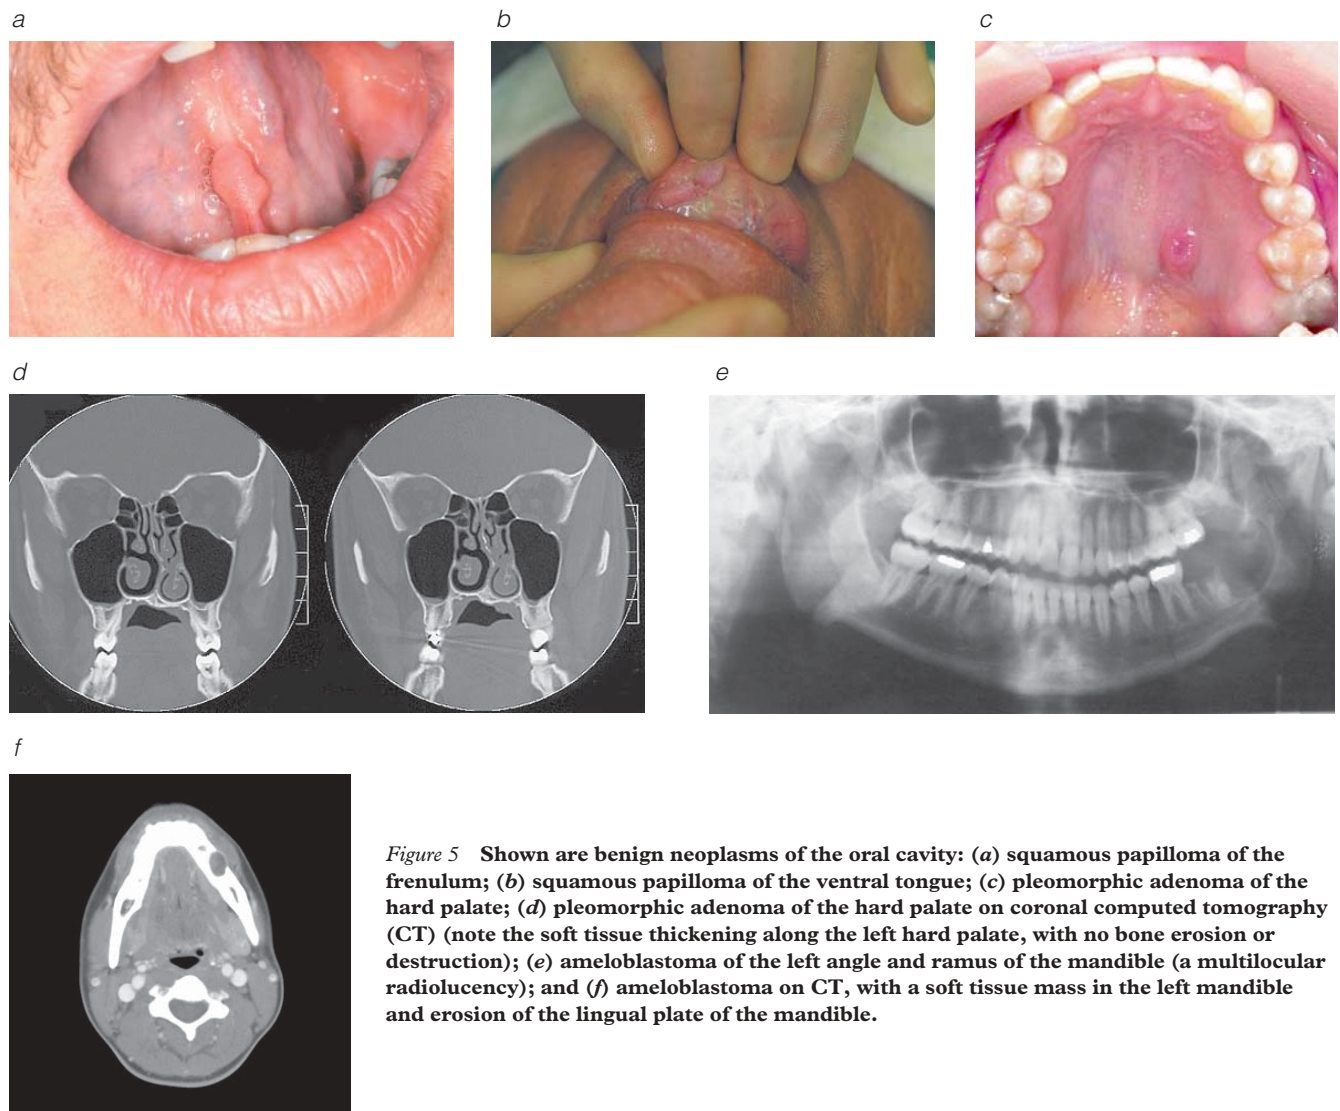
Shown are benign neoplasms of the oral cavity: (a) squamous papilloma of the frenulum; (b) squamous papilloma of the ventral tongue; (c) pleomorphic adenoma of the hard palate; (d) pleomorphic adenoma of the hard palate on coronal computed tomography (CT) (note the soft tissue thickening along the left hard palate, with no bone erosion or destruction); (e) ameloblastoma of the left angle and ramus of the mandible (a multilocular radiolucency); and (f) ameloblastoma on CT, with a soft tissue mass in the left mandible and erosion of the lingual plate of the mandible.
